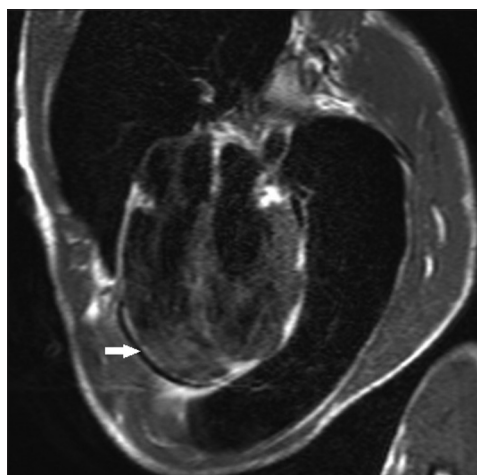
A 23-year-old woman with syncope. Cardiac magnetic resonance Turbo spin-echo T1-weighted image, showing fatty infiltration (arrow) of the myocardium.
